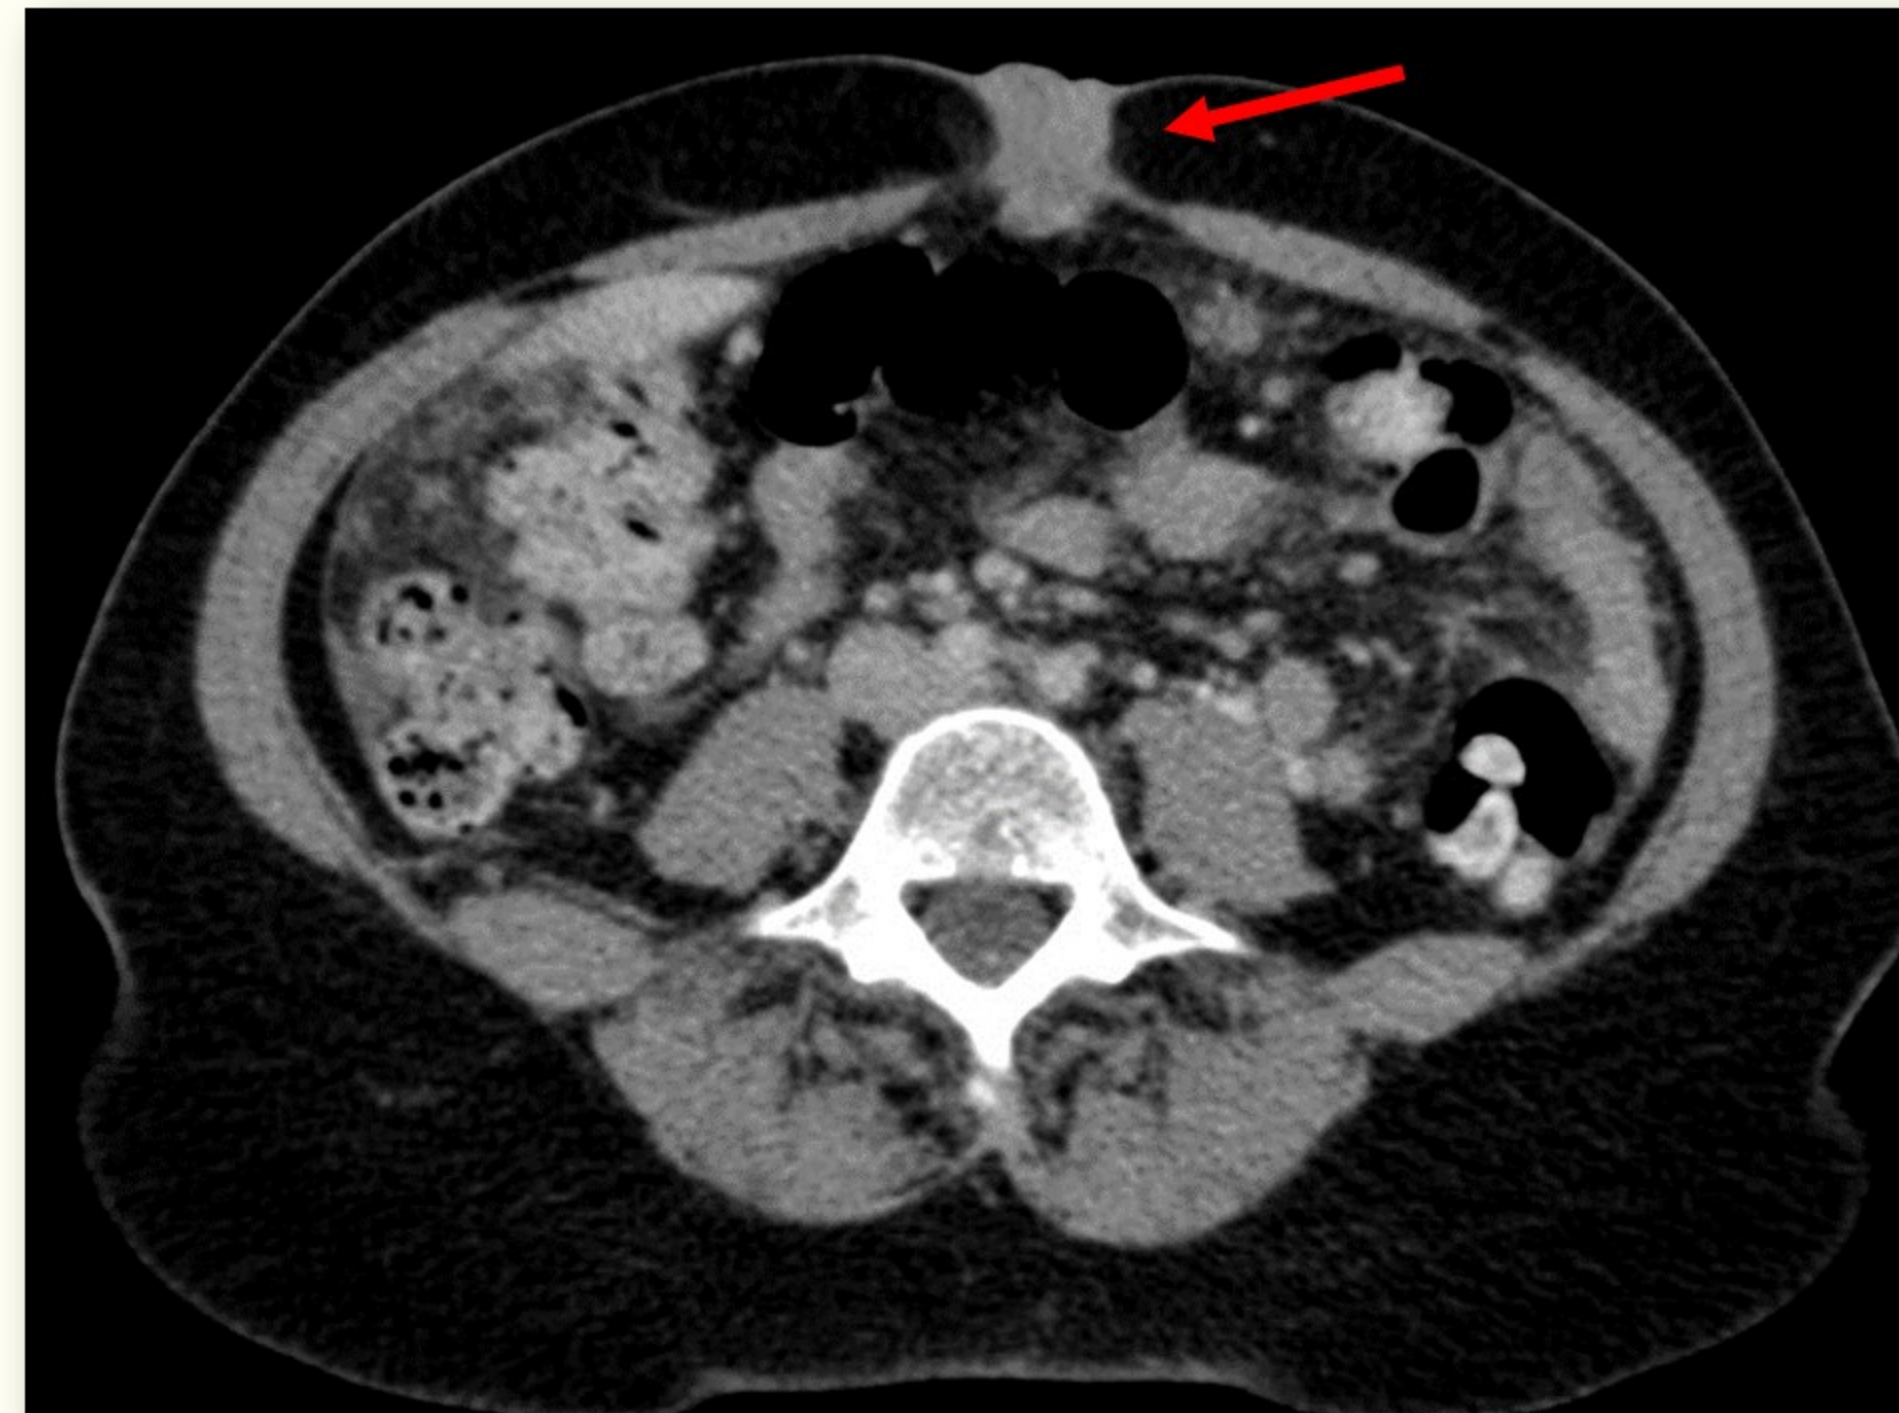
CT Abd/Pelvis with contrast:
